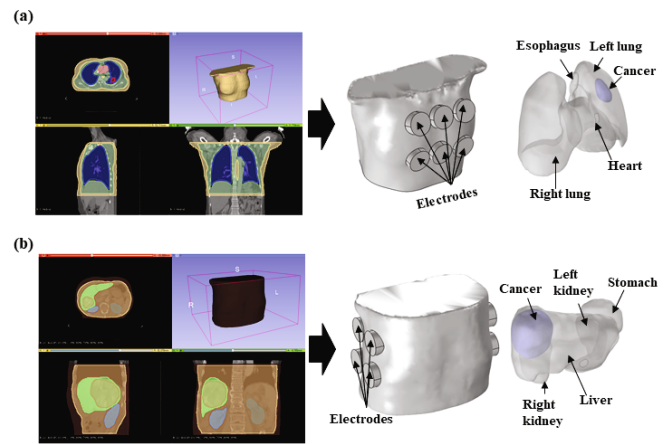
(Color online) Interior and exterior of the patient model created based on CT data for patients with (a) lung and (b) liver cancer.
